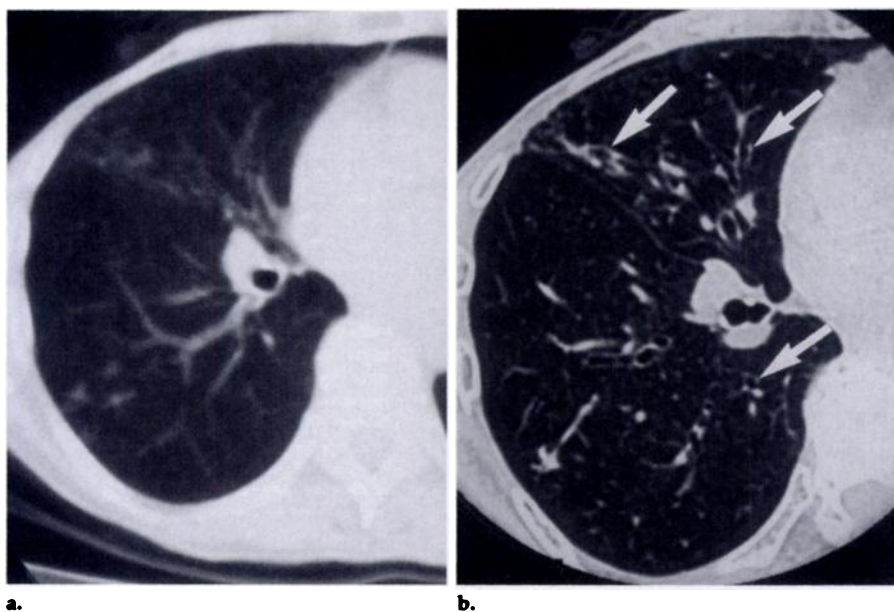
(a) Conventional CT and (b) HRCT scans obtained at the level of the right middle lobe bronchus in a 77-year-old woman. Nodular infiltrate is seen in both scans, but bronchiectasis (arrows in b) can be identified confidently only with HRCT.
